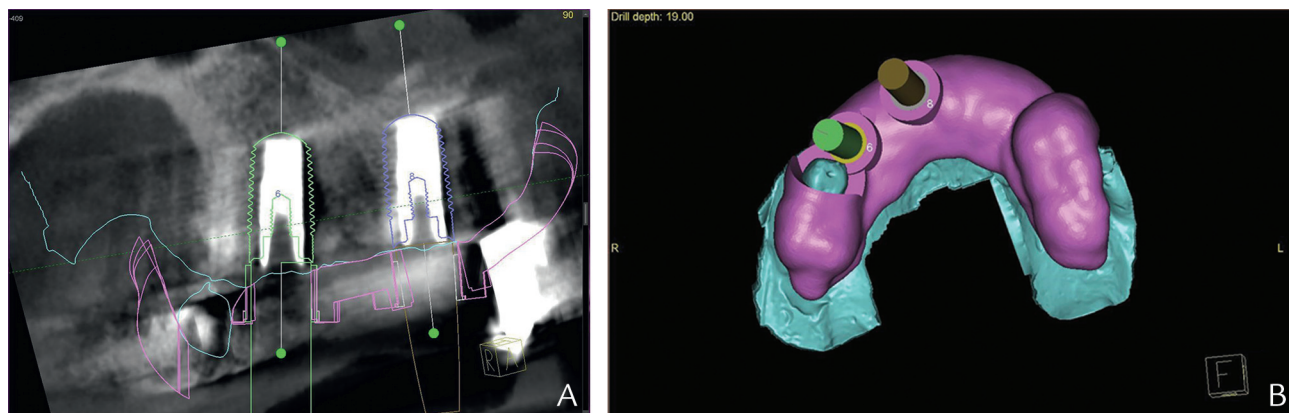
Planning implant removal guided surgery. A, Larger implants were used to represent size of trephine drill (CBCT scan). B, Posterior implant-supported prostheses used to support implant removal guide (3-dimensional design based on CBCT scan).
